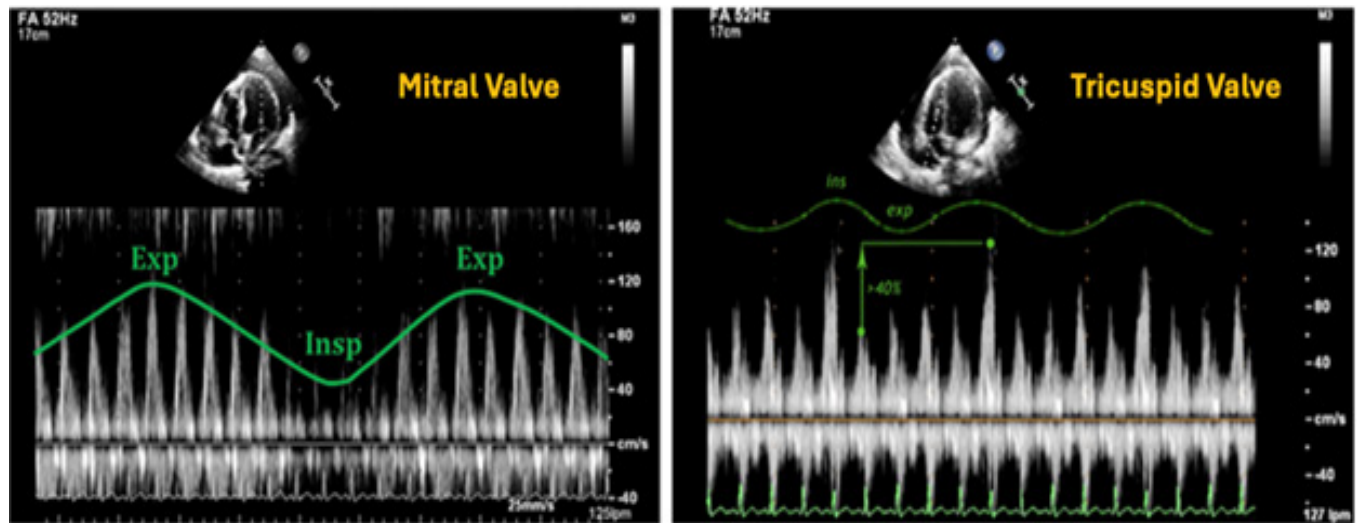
Doppler evaluations of respiratory variations (Adapted from Reference 3). In the presence of cardiac tamponade, the peak filling velocities of the mitral and tricuspid valves demonstrate respiratory variation due to the shifting balance of intrathoracic and intracardiac pressures.
